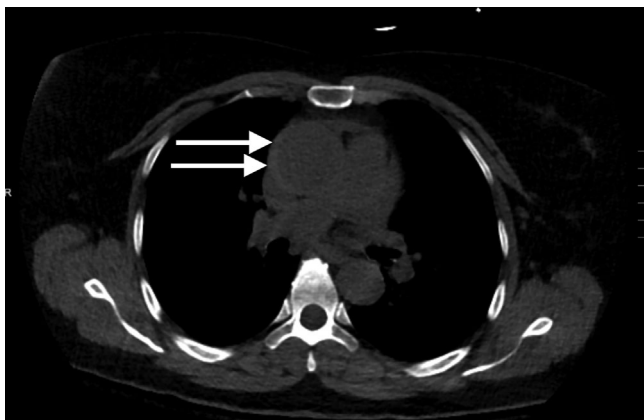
Computed tomography of the chest showed a crescent-shaped area with relative hyperattenuation in the ascending aorta.
